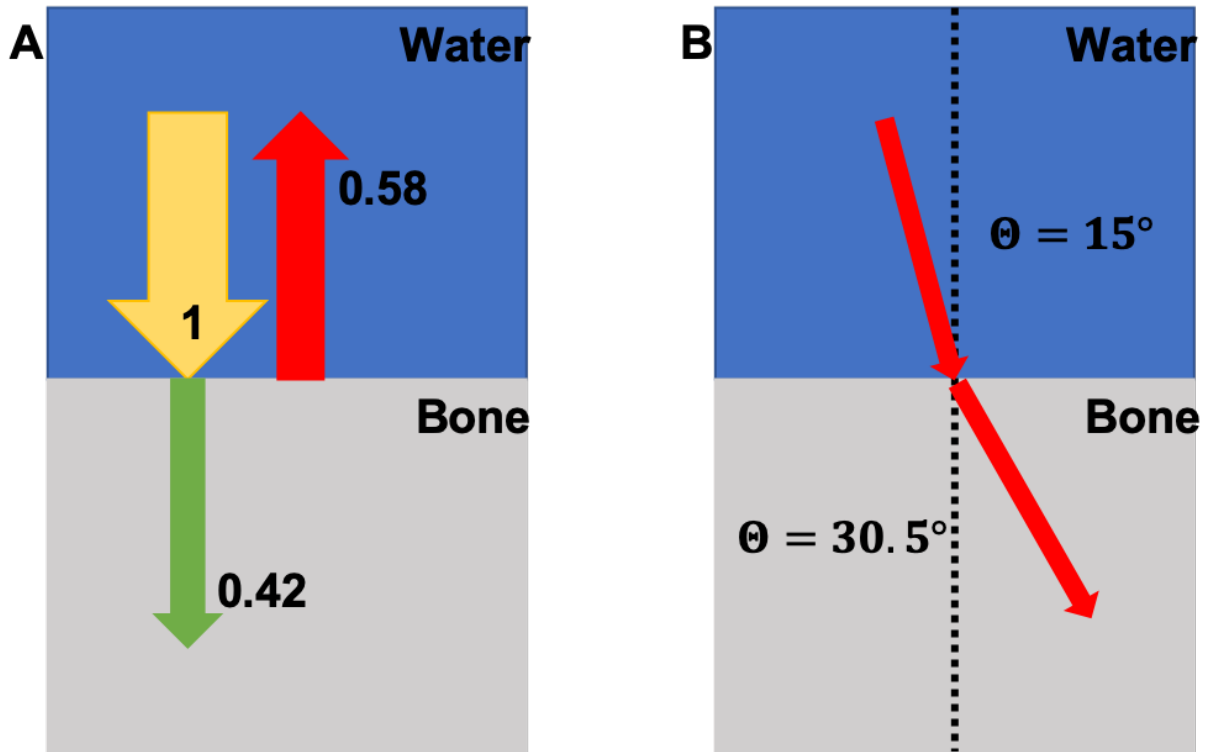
A: An example of the transmission and reflection of an ultrasound wave at a water bone interface. 58% of the incoming wave will be reflected off the interface due to the acoustic impedance mismatch between the materials. B: An example of the refraction of the wave due to speed of sound mismatch between materials.
